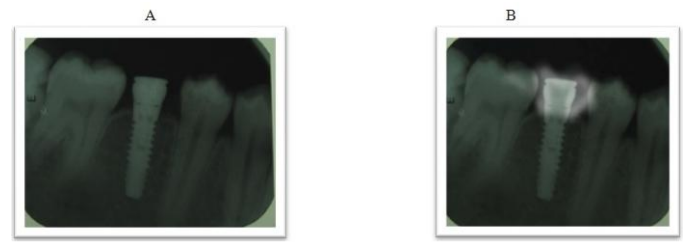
Periapical radiograph taken immediately (A) and 1 year (B) after implant placement.
